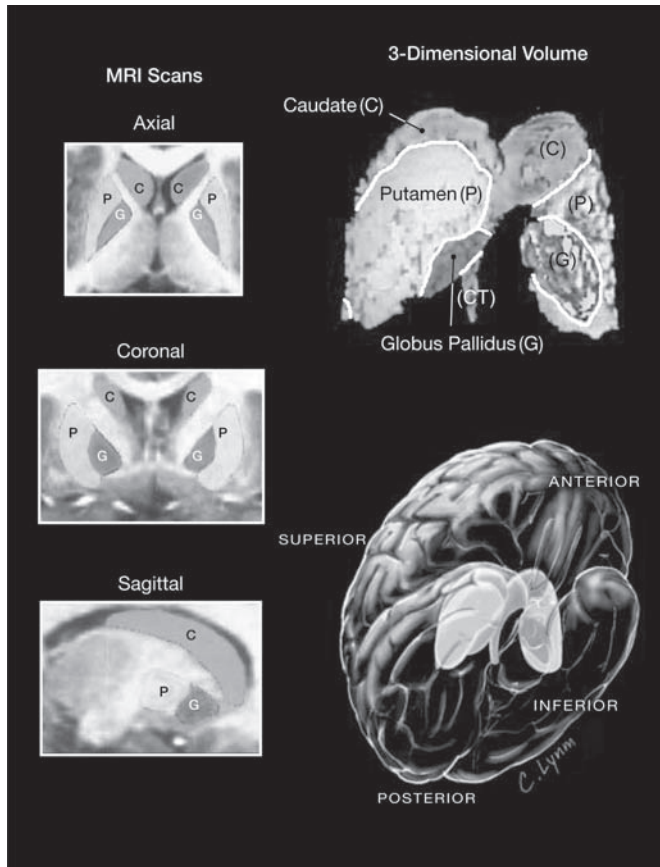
Neuroimaging techniques such as MRI are used to quantify brain structures and regions. The basal ganglia, consisting of the caudate, putamen, and globus pallidus, are particular regions of interests for many neurodevelopmental disorders. These subcortical structures can be isolated and measured via MR quantitative analysis techniques. C, caudate; CT, caudate tail; G, globus pallidus; P, putamen. From Peterson et al. (2003). Copyright 2003 by the American Medical Association. Reprinted by permission.
